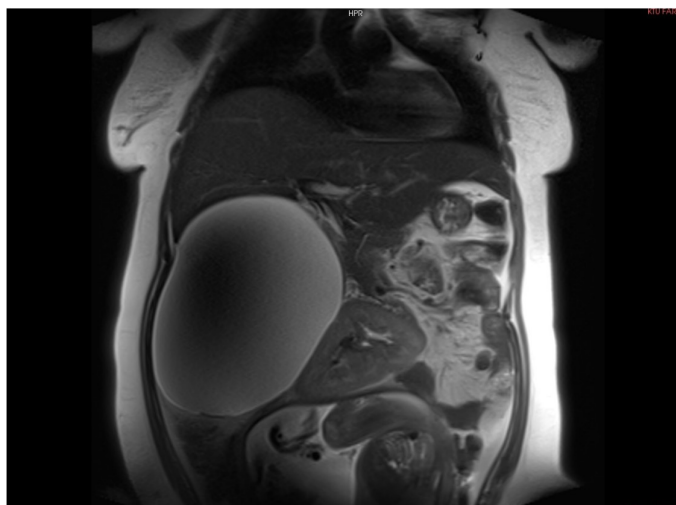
Coronal image of the adrenal cyst, displacing the right kidney (obtained from MRI studies)
